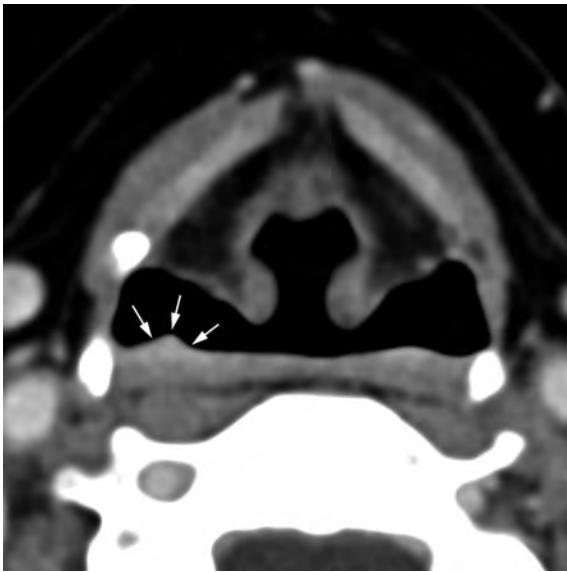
Axial contrast-enhanced CT image performed during Valsalva maneuver reveals a tiny mass along the posterior pharyngeal wall (*arrows*) on the right side that would have been difficult to detect with collapsed piriform sinus as typically seen during quiet breathing
